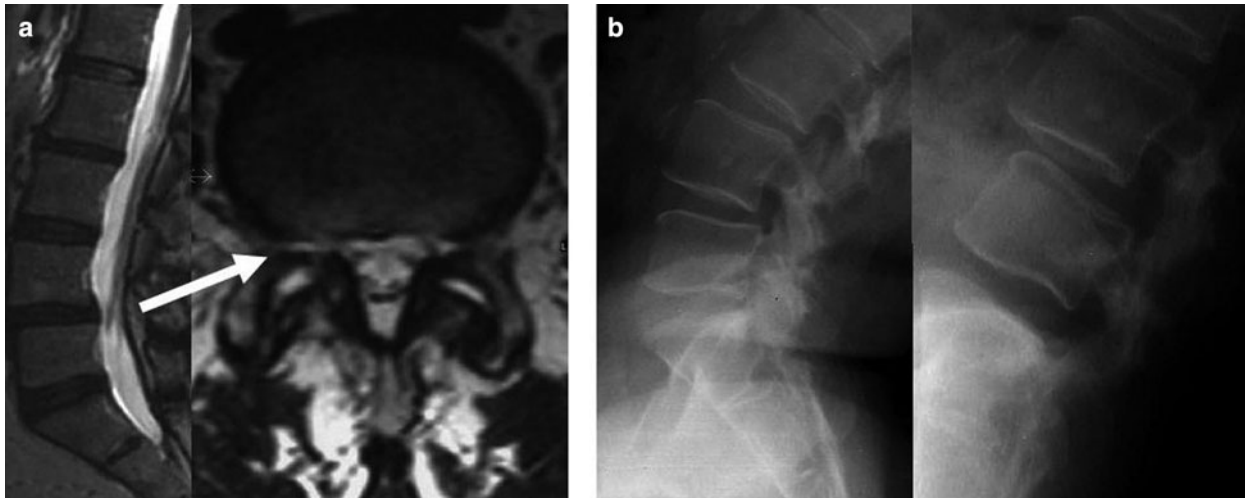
Minimal signs of spondylolisthesis (white arrow) can be appreciated in sagittal and axial T2-weighted MRI (a). Dynamic orthostatic X-ray confirms aretrollisthesis of L5 (b)
